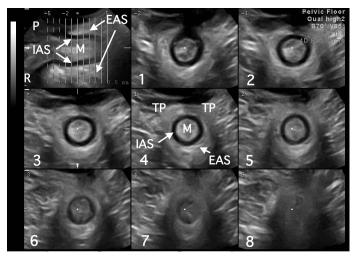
Normal appearances of the anal canal in a nulliparous patient as seen on translabial tomographic ultrasound. The top left image shows the midsagittal plane, the remaining eight slices are placed from just above the EAS (slice 1) to just below the IAS (slice 8), encompassing the entire EAS. Reproduced with permission.²
